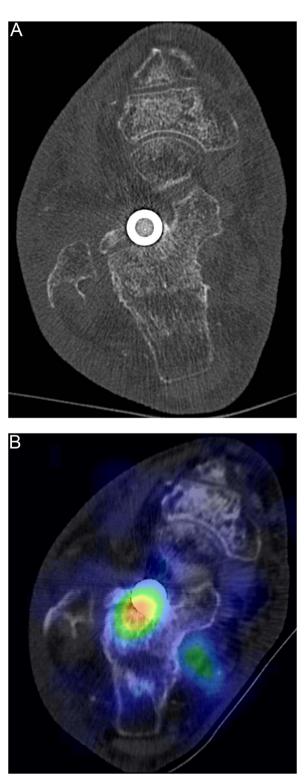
Correct identification of an osteosynthesis-associated infection with ^{99m}Tc-antigranulocyte SPECT/CT.
